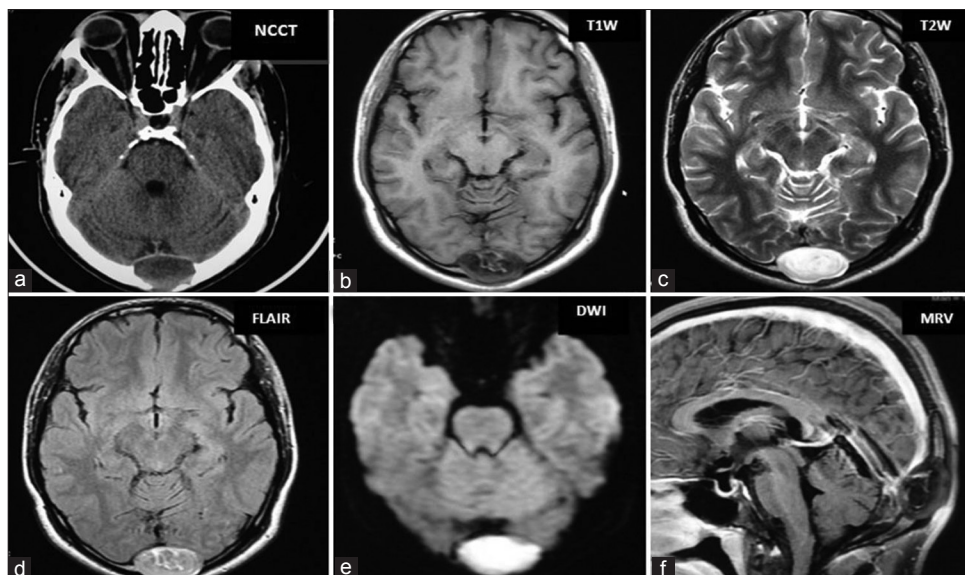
Computerized tomography of head (plain) showing a well-defined midline occipital intradiploic hypodense mass causing expansion of diploic space and lytic defect of both tables of occipital bone; Magnetic resonance imaging brain showing an oval lesion in the occipital intradiploic space in midline which is Hypointense on T1W, Hyperintense in T2W, heterogeneous signal in FLAIR, restricted diffusion in diffusion weighted imaging (DWI), non-enhancement of the lesion and compression of torcula herophili on post-contrast magnetic resonance venogram (MRV)
